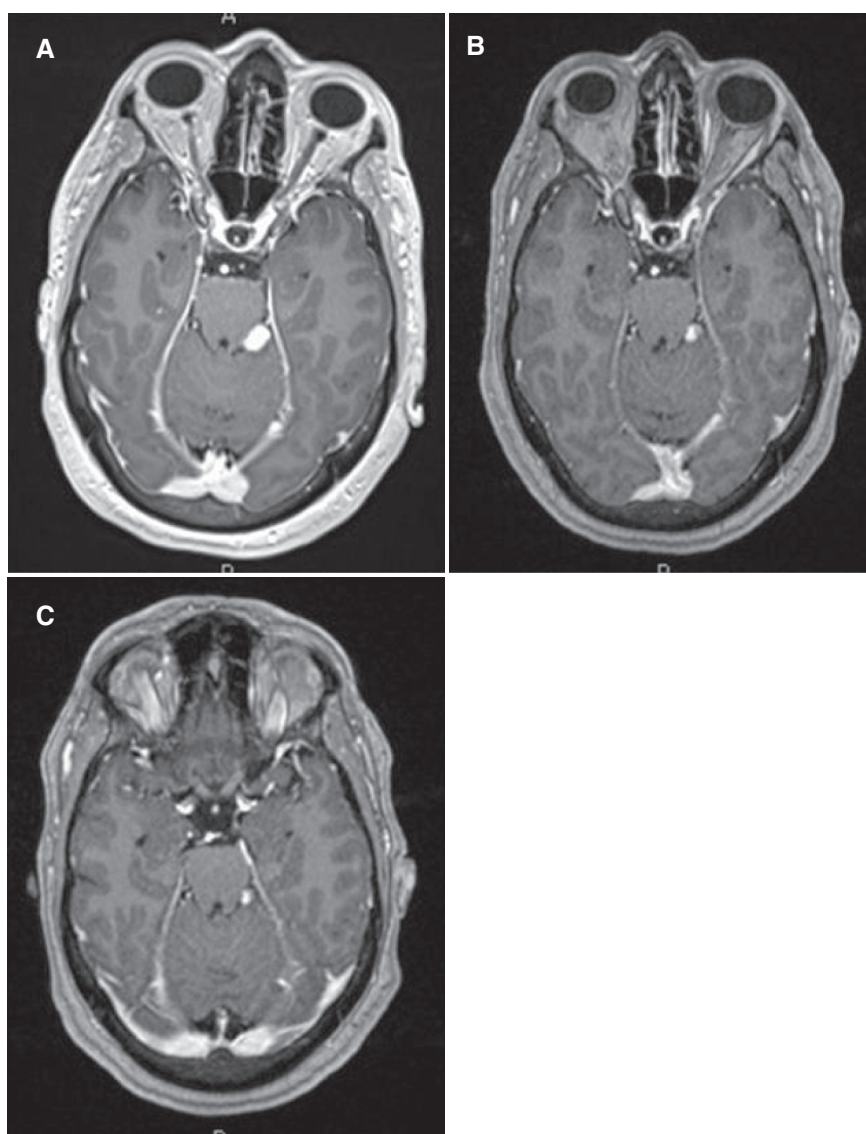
Radiographic response of Central nervous system (CNS) hemangioblastoma treated with belzutifan. (A) Axial T1 post-contrast MRI demonstrating a left peri-pontine enhancing lesion consistent with a hemangioblastoma on baseline imaging. (B) A notable decrease in size is observed 40 days after initiating belzutifan. (C) There is a further slight decrease in size observed 7 months after initiating belzutifan.
